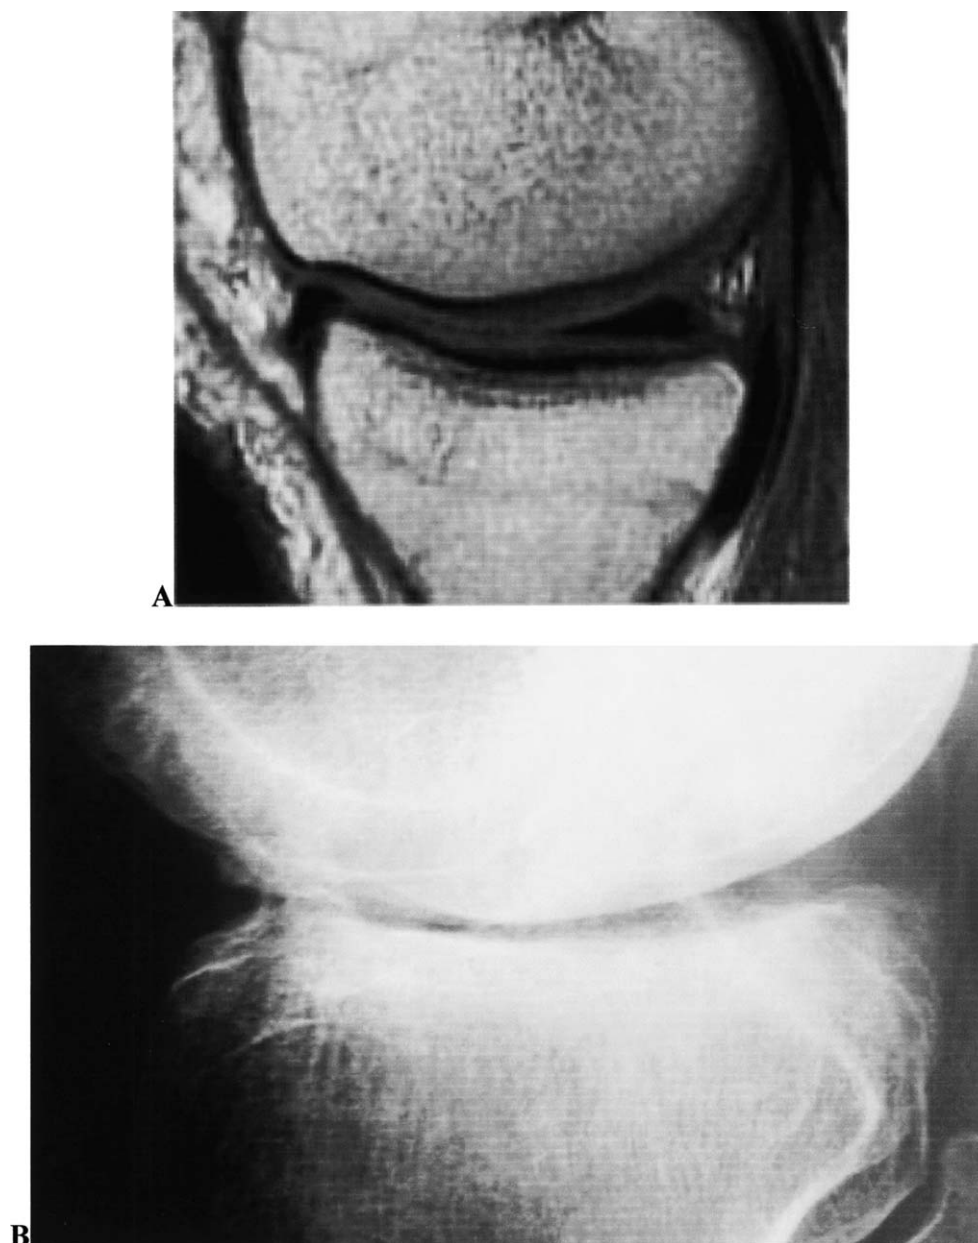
In the extended knee position the femoral condyle rolls onto the anterior rim of the tibial plateau, in this position the joint space comprises the combined thickness of the femoral, tibial and meniscal cartilages, as shown in (A) a sagittal MRI scan of the medial tibiofemoral compartment and in (B) a lateral radiograph of an OA knee where the loss of cartilage results in the condyle resting on the bony ridge of the tibia producing a true space visible in the centre of the compartment.
